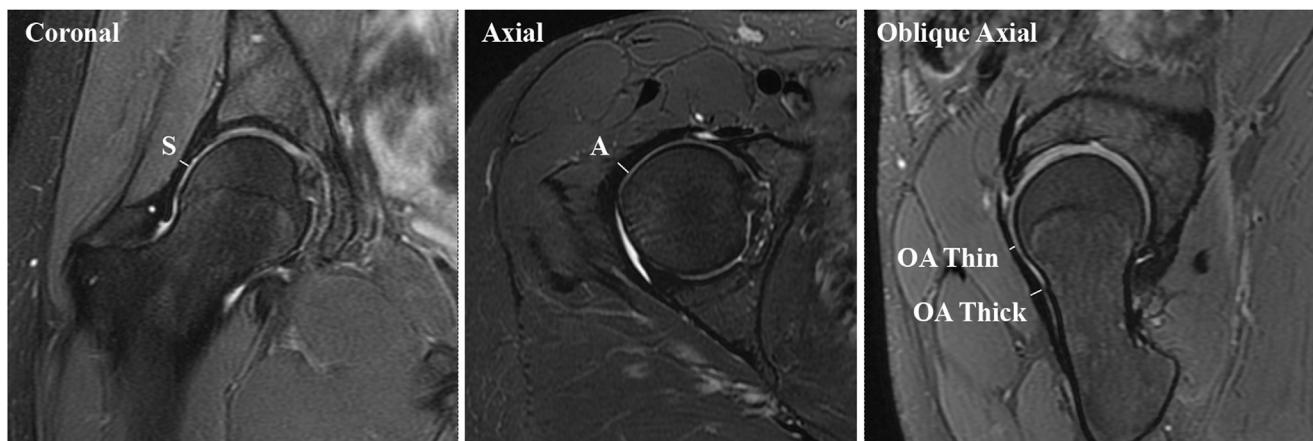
Hip joint capsule measurement technique. Coronal and axial fat-suppressed T2-weighted sequences, and oblique axial proton-density fat-suppressed sequences of a routine (right) hip magnetic resonance imaging with the following measurements: thinnest portion of the superior joint capsule on the coronal plane at 12 o'clock (S), thickest portion of the anterolateral joint capsule on the axial plane at 3 o'clock (A), and thinnest (OA Thin) and thickest (OA Thick) portion of the anterior joint capsule on the oblique axial plane at 3 o'clock.
